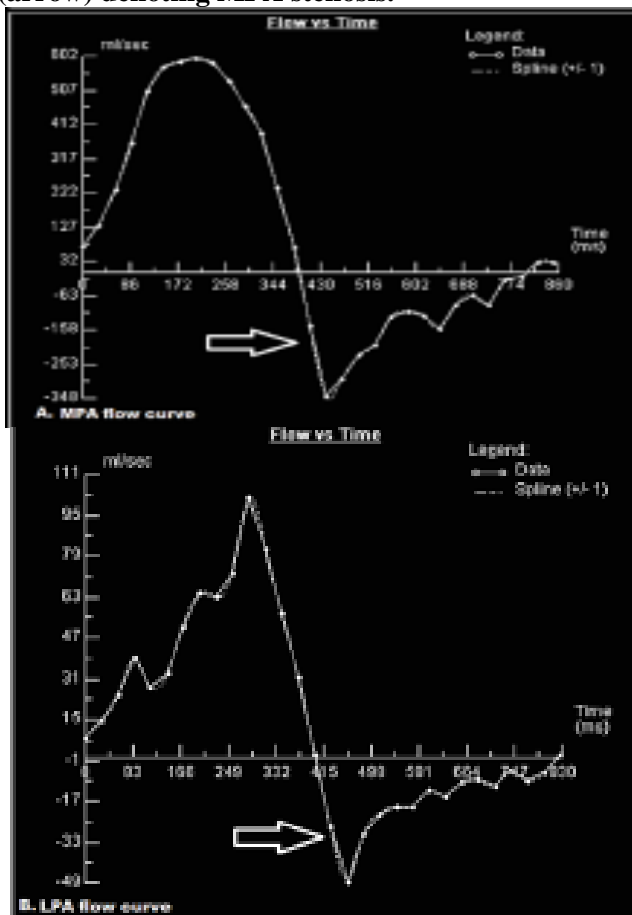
Flow vs. time curve obtained from MRI phase contrast study, (A) shows MPA regurge (arrow), (B) shows LPA regurge (arrow).
